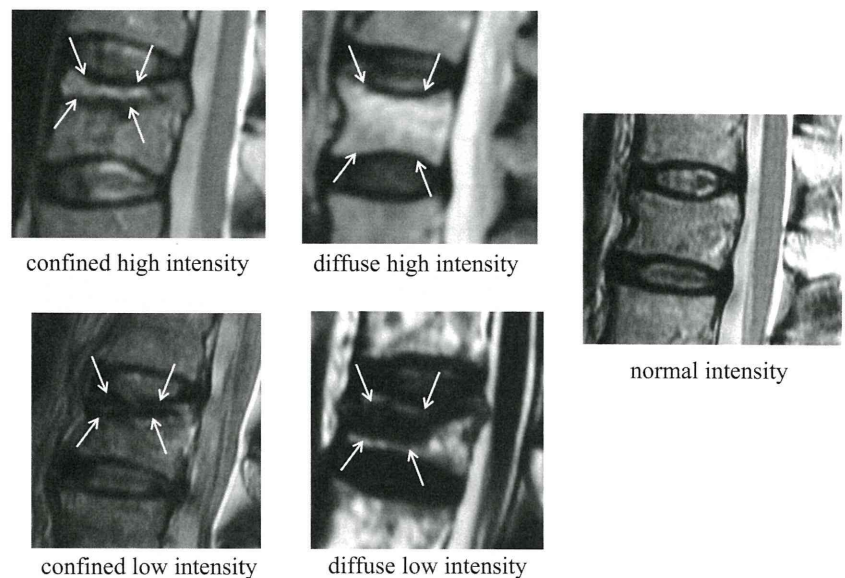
Intensity changes of the fractured vertebral bodies on T2-weighted MR images were classified into five patterns: confined high intensity type, diffuse high intensity type, confined low intensity type, diffuse low intensity type, and normal intensity.
